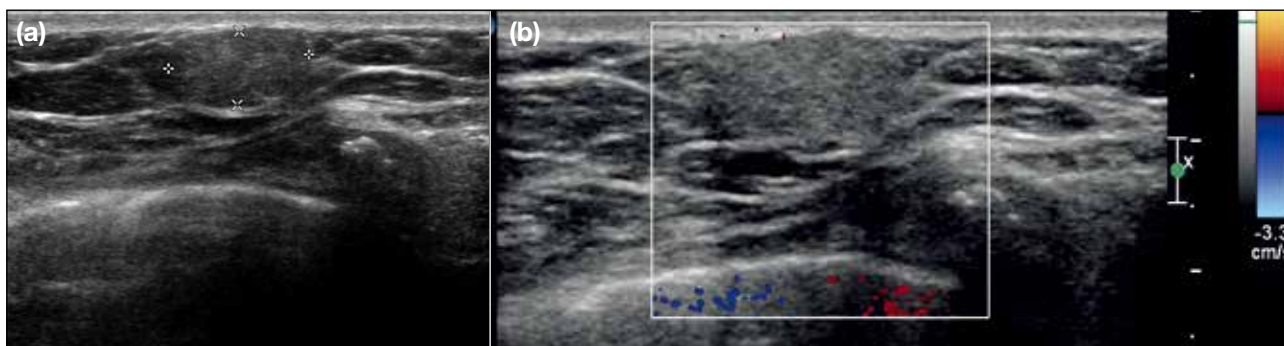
(a, b) A 60-year-old woman presented with a small nodule attached to the skin over the left breast. Sonography showing an echogenic lesion just beneath the skin. Biopsy confirmed presence of a sebaceous cyst.
